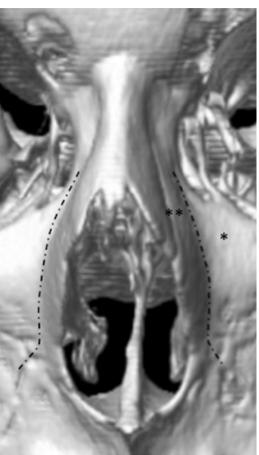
Anatomy of the nasal parentheses. Frontal facial CT scan with 3D bone reconstruction of the nasal pyramid. The basal groove (dotted line) separates the body of the maxillary bone (*) from its frontal apophysis () on the facial skeleton and is a border of nasal bone pyramid implantation.
